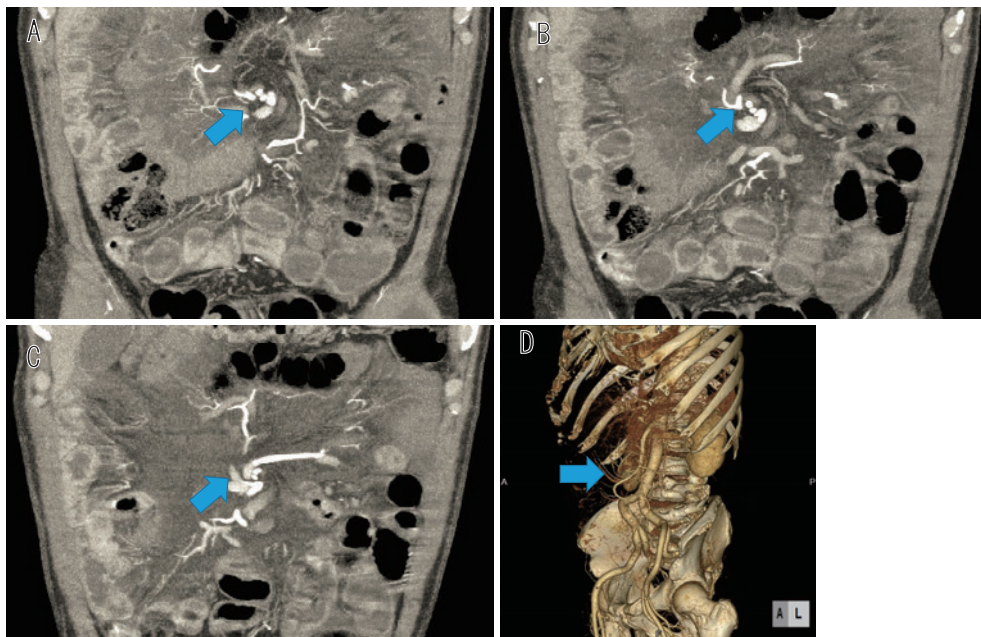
Abdominal CT (frontal plane)
